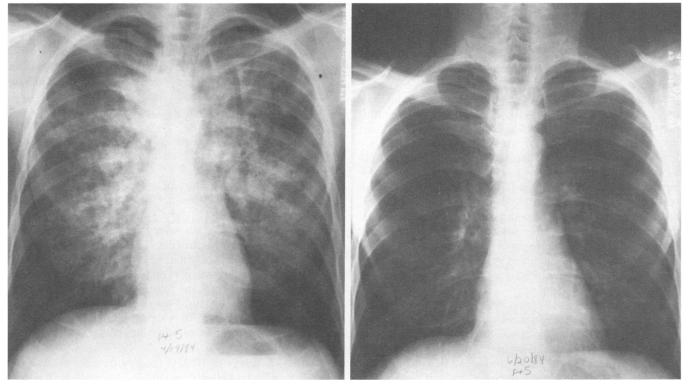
Chest roentgenograms in patient 5, before (left) DFMO therapy for recurrent *Pneumocystis* pneumonia showing diffuse infiltrates and after (right) eight weeks of treatment with DFMO showing resolution of infiltrates.
